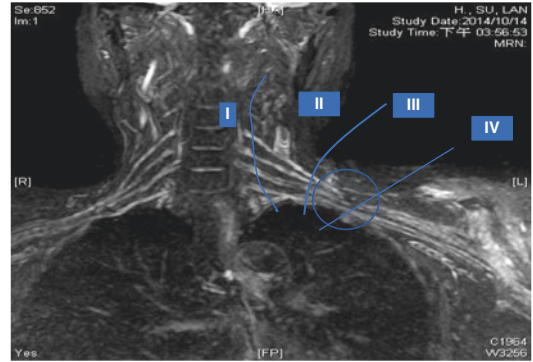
New classification of level of brachial plexus injury in MRI. The MRI shows that the lesion is located in level III
